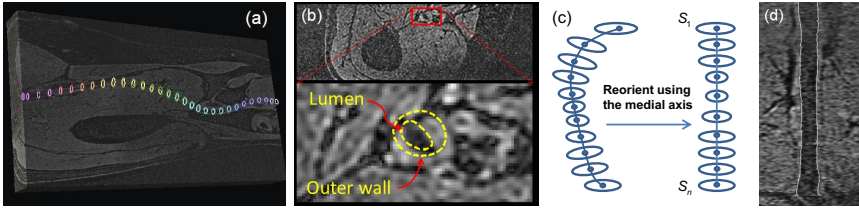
(a) An example 3D femoral MR image with manual delineations; (b) A transverse slice of a 3D femoral MR image with manual delineations; (c) Reorientation of the femoral MR image using the medial axis of the artery. The reorientation procedure is described in Section 3; and (d) Long axis view of reoriented 3D MR image.
